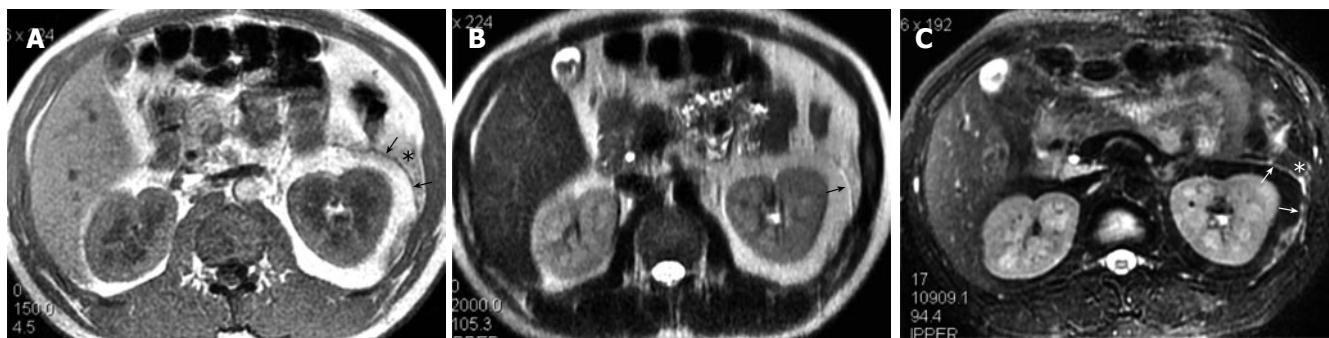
The same patient as in Figure 3. At the level of the head of the pancreas, left renal fascial plane (arrow) and anterior pararenal space fat stranding (asterisk) present on GRE in-phase (A), SSFSE T2-weighted (B) and R-T T2-weighted (C) images, but they are most prominent on R-T T2-weighted image.
